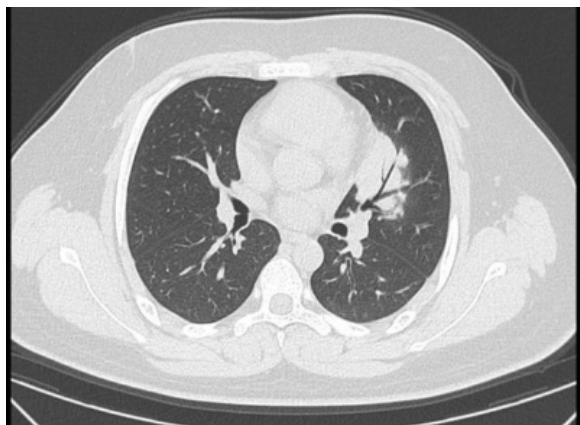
Chest CT image of the patient.
